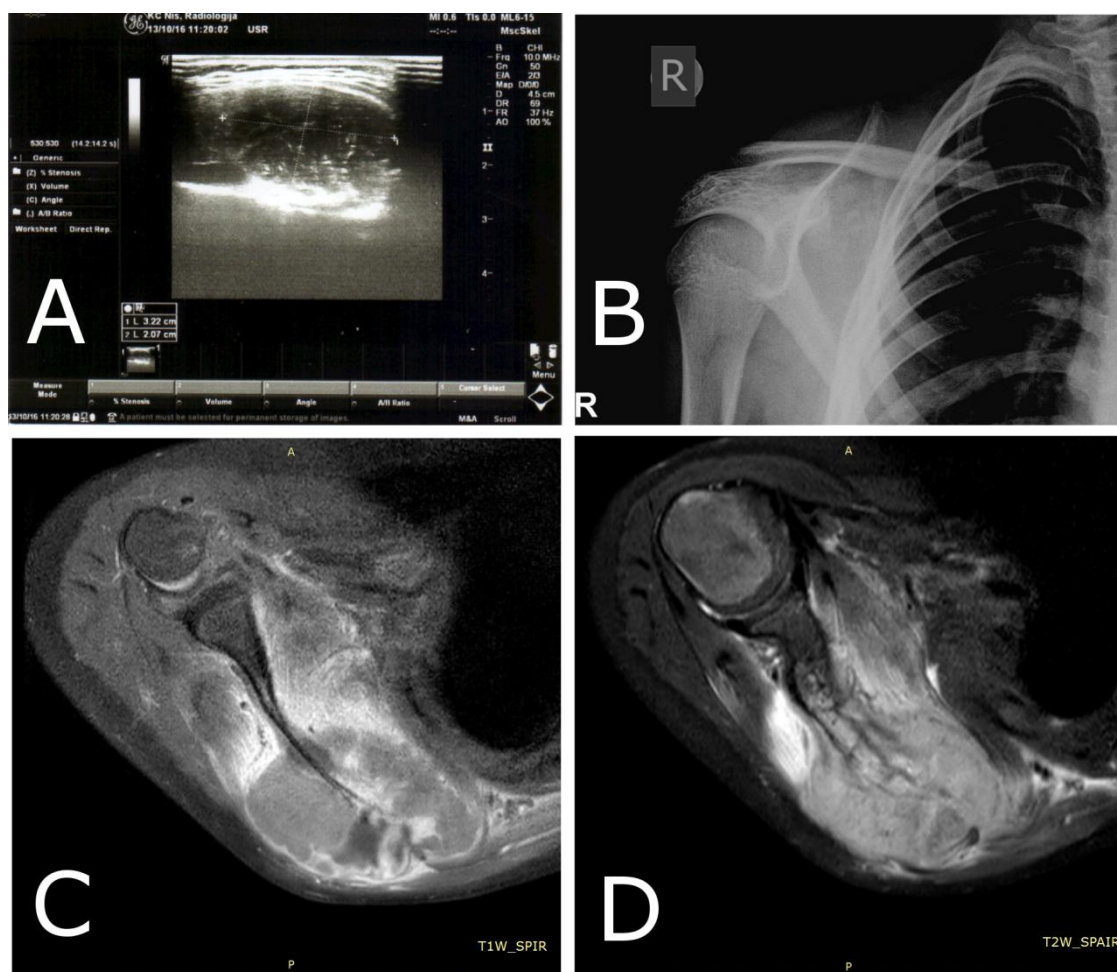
A) Inhomogeneous mass on ultrasound of right scapular region (Case 2). B) Plain X-ray of right scapula with permeative lesions without sclerosis. C-F) MRI findings of the same patient. C) Large soft tissue mass on transverse section. D) Infiltration of body of scapula and subscapularis muscle on coronal section. E) Bone and muscular infiltration on transverse f-stir section and F) sagittal section.
